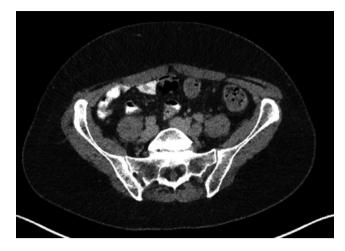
CT with infra-diaphragmatic lymphadenopathy
